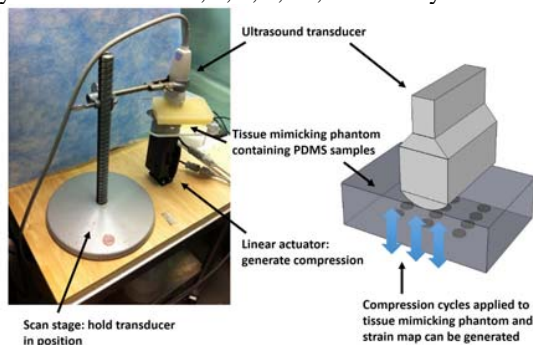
Ultrasound elastography (UE) experiment setup
